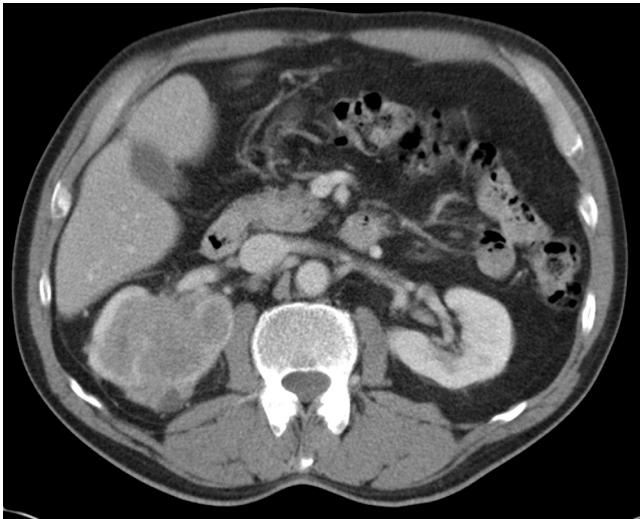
■ Chromophobe tumour. Post-contrast CT demonstrates a large enhancing right renal mass which was confirmed following nephrectomy as a chromophobe renal cancer. The appearances are indistinguishable from that of a clear cell cancer. Chromophobe tumours have a better prognosis than clear cell carcinoma.
